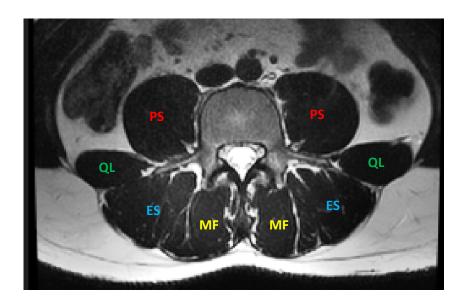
Axial MRI image depicting the psoas (PS), quadratus lumborum (QL), erector spinae (ES) and multifidus (MF) muscles.
